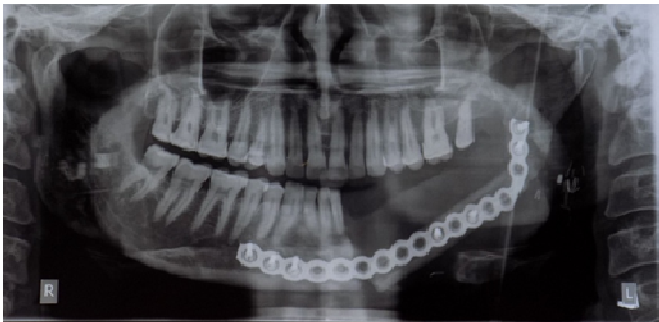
Orthopantomogram showing grafted bone with a reconstruction plate on the left mandibular side
